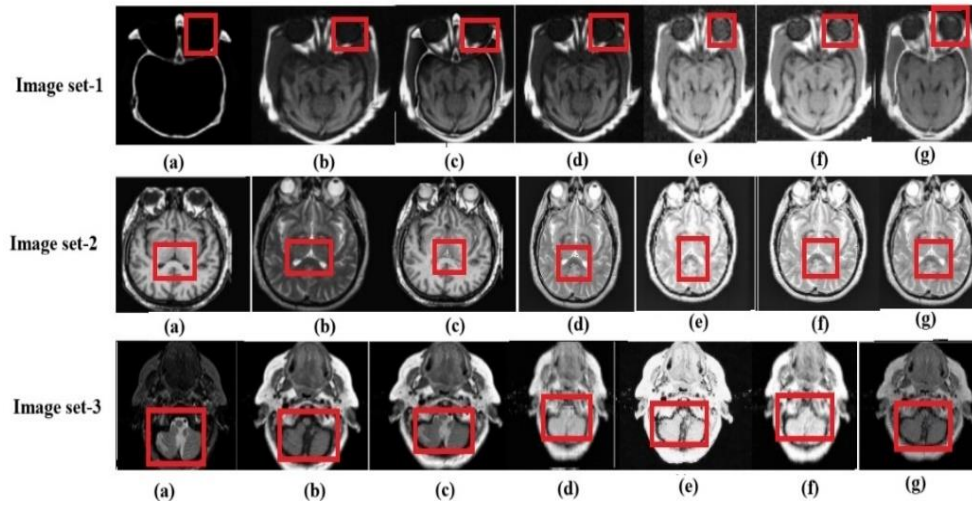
Comparison of fused images of suggested model with recently developed MMIF model ((a) source image (CT) (b) source image (MRI) (c) output of fusion model [140] (d) proposed model (PCA [13]) with Ac func-1 (e) proposed model (PCA [13]) with Ac func-2 (f) proposed model (mean-max [85]) with Ac func-1 (g) proposed model (mean-max [85]) with Ac func-2)
